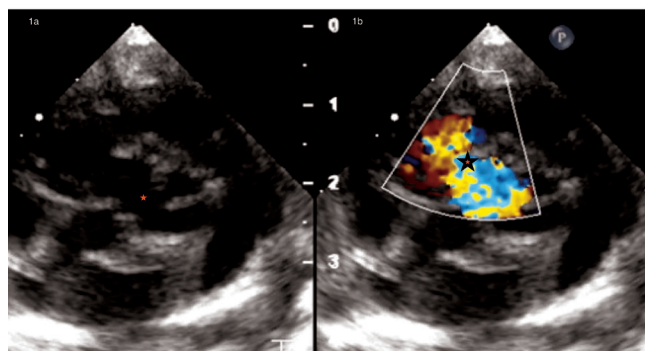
Parasternal short axis view of echocardiography revealed the presence of peri membranous ventricular septal defect (red asterisk) measuring 3mm with left to right shunt
